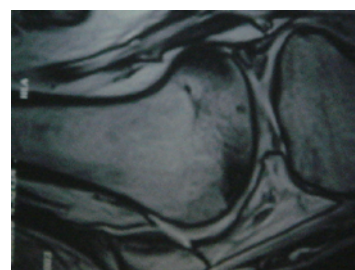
Coronal MRI for the same patient showing affection of the articular surface.
